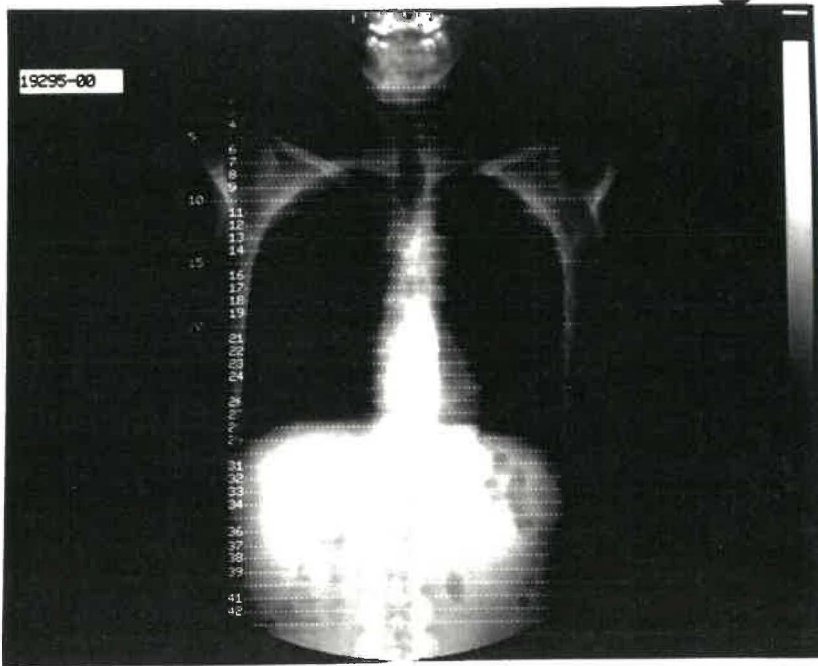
X-ray image and the position levels where x-ray CT images were taken from a patient.
